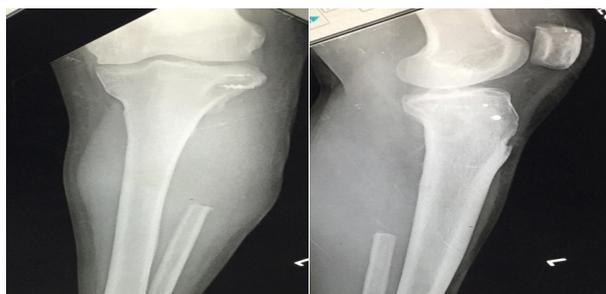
six months follow up x-rays shows fibula is free of tumour recurrence
